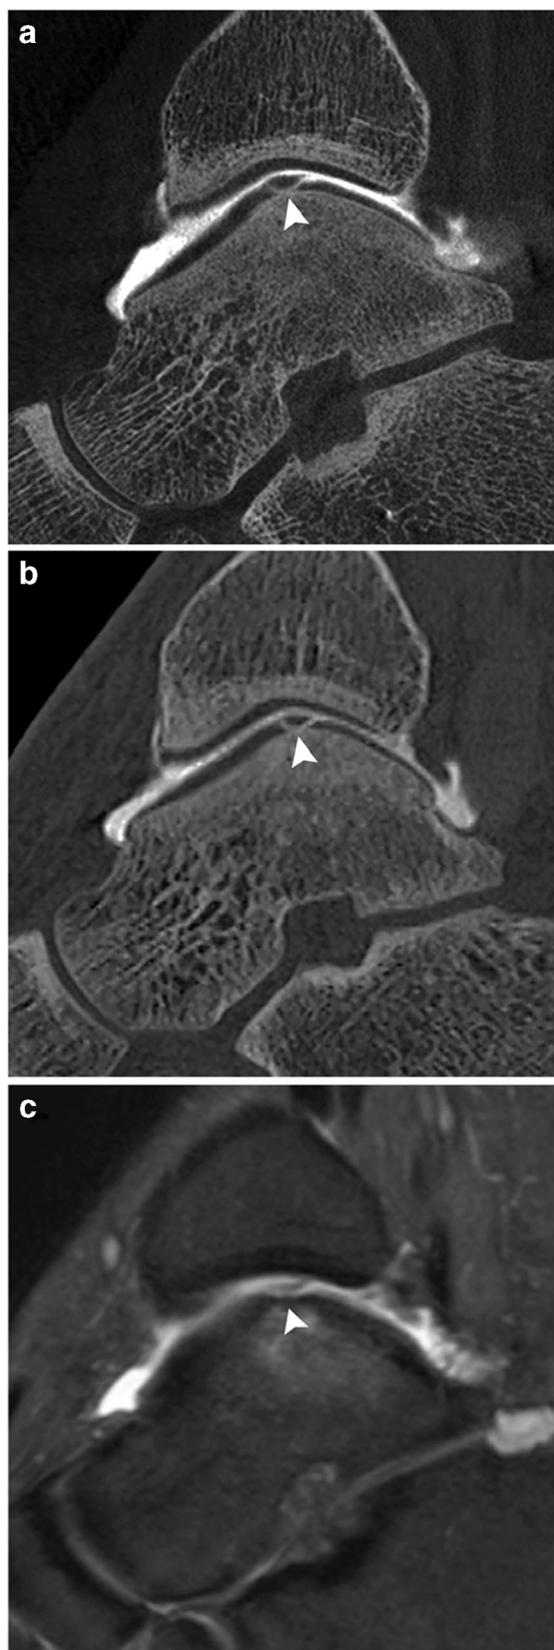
Sagittal reformatted FPCT (Fig. 2a), MDCT (Fig. 2b), and MR (Fig. 2c) arthrography images exhibiting a chondral flap of the talar dome (arrowhead). Of note, MR image allows detection of cartilage defect but does not permit fine assessment of the flap
